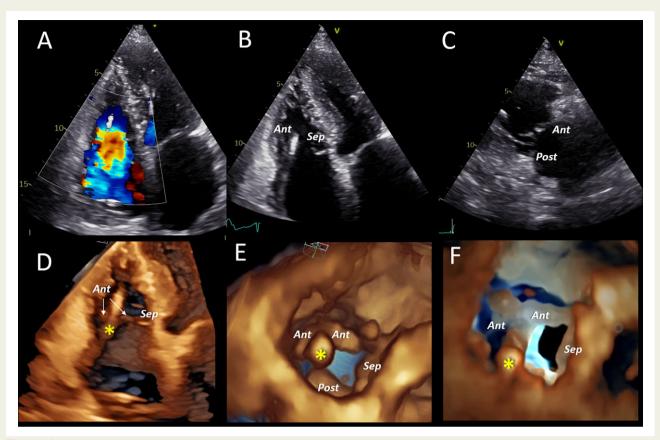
Examples of cardiac implantable electronic device imaging. (A) A 4-chamber view colour Doppler image showing torrential TR in a patient with pacemaker (PM). (B) A 4-chamber view showing no apparent interference of PM catheter with anterior (Ant) and septal (Sep) leaflet, which are severely tethered and not coapting. (C) A RV inflow view showing the anterior (Ant) and posterior (Post) leaflets. The PM catheter can only be visualized at its most distal part. (D) A RV inflow 3D rendering showing a possible interference of PM catheter (asterisk) with anterior leaflet (Ant). (E) A TV 3D en face views during systole from the ventricular perspective clearly show the PM catheter (asterix) impinging the anterior leaflet (Ant) in its mid part. (F) The same view as (E), with transillumination slightly tilted to display the close spatial relationship between PM lead (asterix) and anterior leaflet (Ant).
